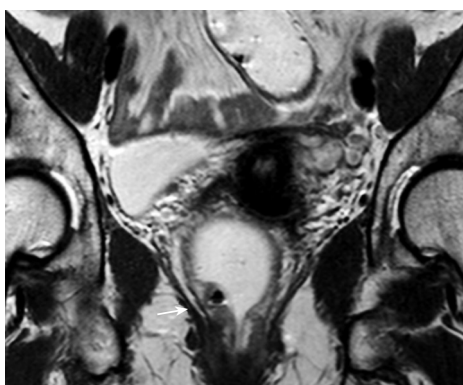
Magnetic resonance imaging shows a T1-weighted of low signal area (arrow) growing in the anterior portion of the anorectal junction.
